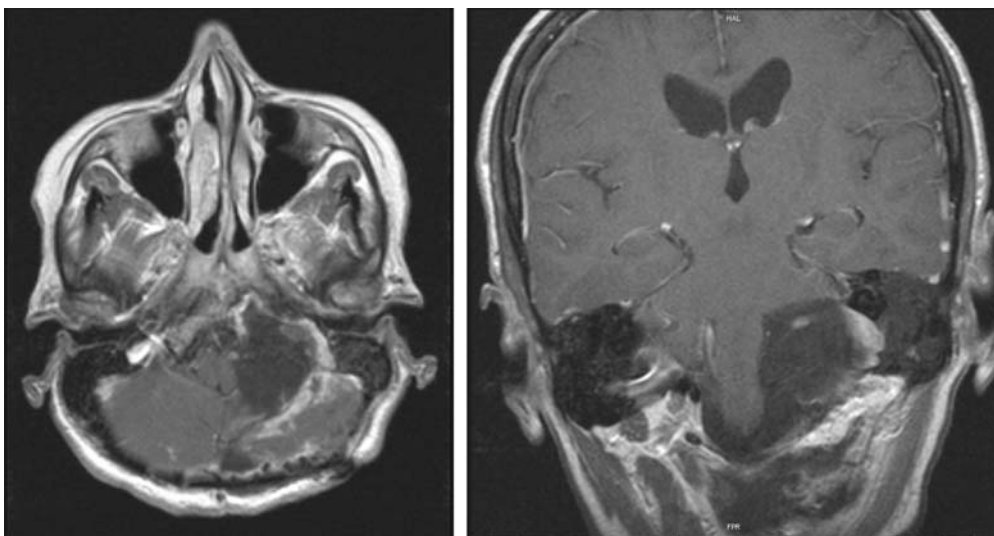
Early postoperative axial (*left*) and coronal (*right*) T1-weighted Gd-enhanced MRI demonstrating the complete removal of the hypoglossal tumor via the STA approach
